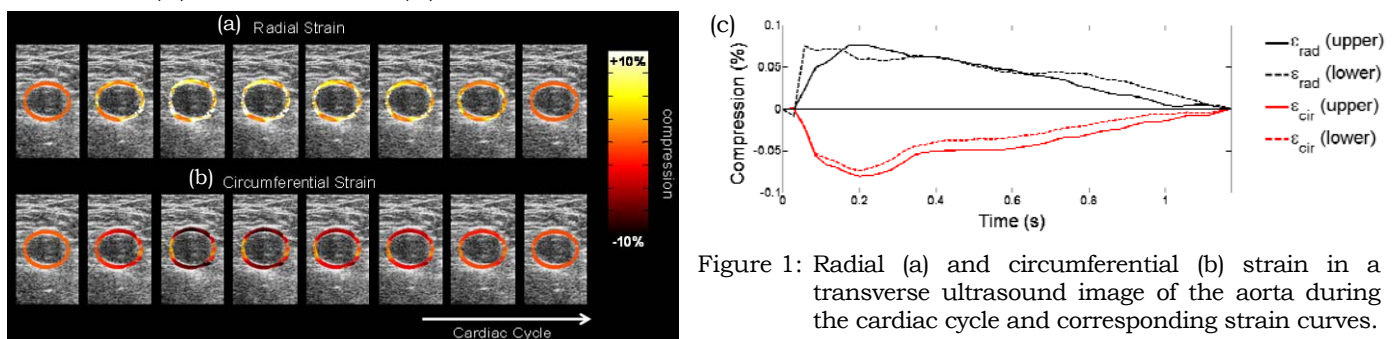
Radial (a) and circumferential (b) strain in a transverse ultrasound image of the aorta during the cardiac cycle and corresponding strain curves.
